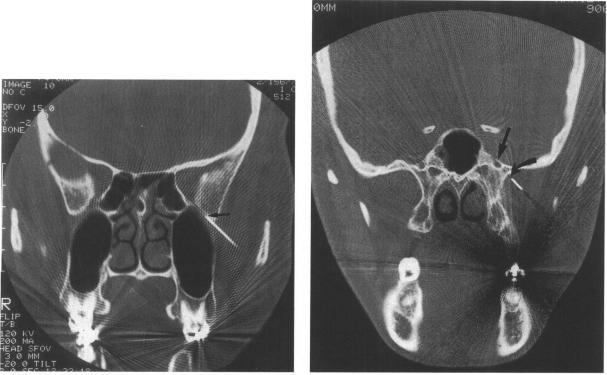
A: Coronal CT images through the orbital apex. The tip of the needle (arrow) is seen coursing along the curved lateral wall of the maxillary antrum. B: Coronal CT through the foramen rotundum. This image is obtained posterior to A. The tip of the needle (curved arrow) lies in the pterygopalatine fossa 5 mm from the foramen rotundum (straight arrow).
